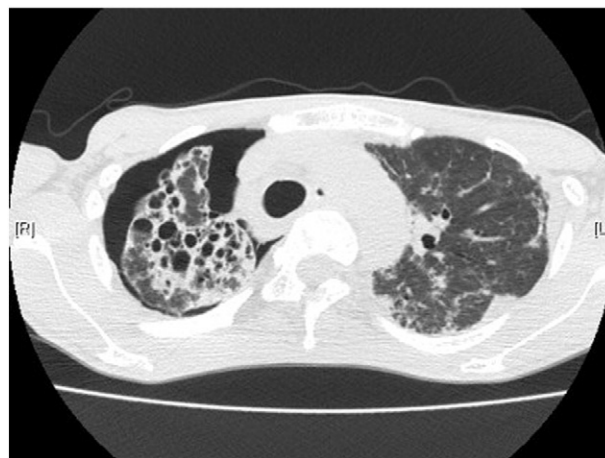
Preoperative chest computed tomography at the level of the tracheal carina shows extensive pulmonary fibrosis with right pneumothorax.
